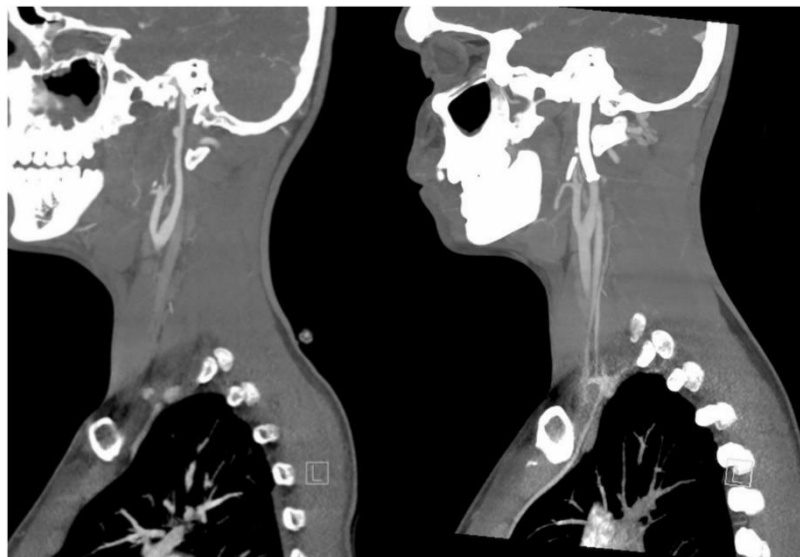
[CT Angiography](#) before and after Intervention Comparison between the neck CT angiography obtained at 48 hours after initial antibiotic therapy (left) and 48 hours after stent placement (right).
